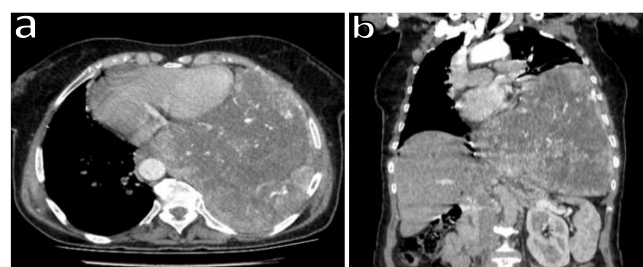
Axial (A) and sagittal (B) thoracic CT images revealing a large tumor mass in the left lower lung lobe
